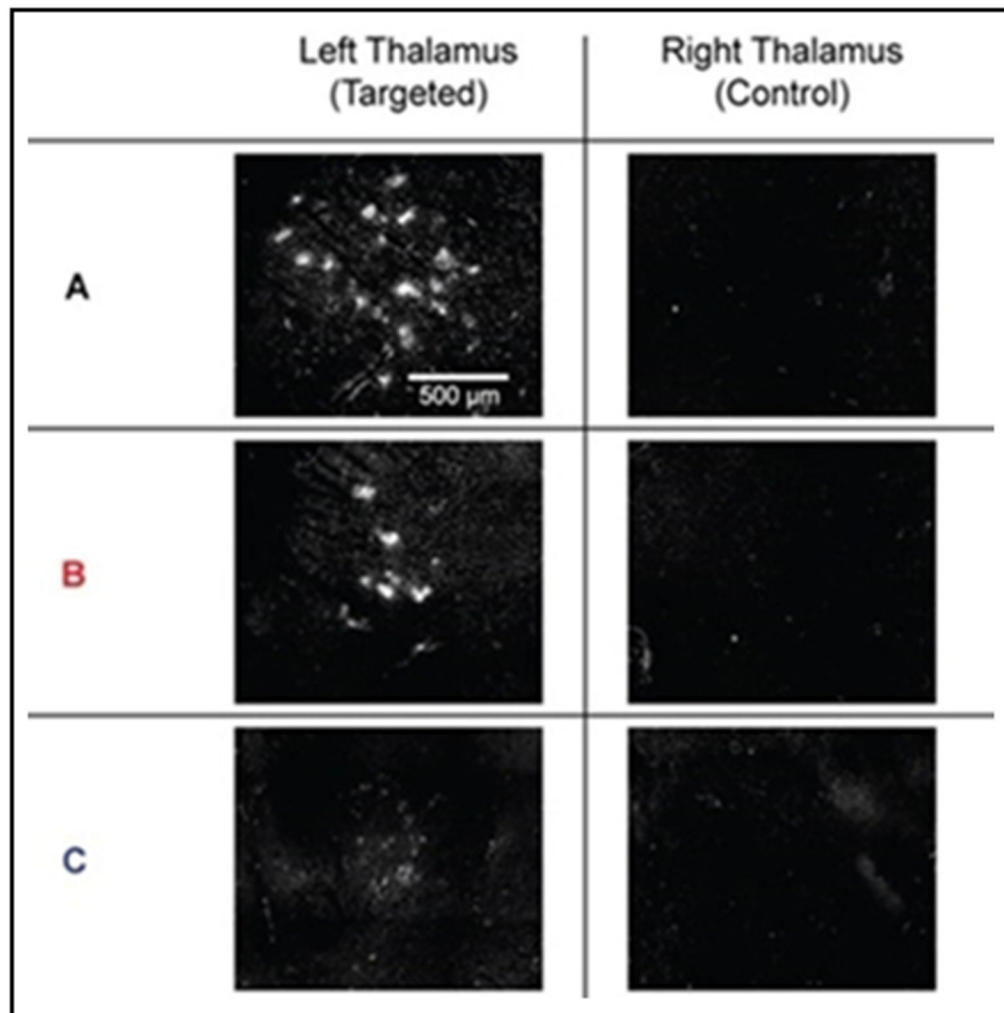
Fluorescence images from the delivery of Cy5-DNA-Au NPs across the BBB using focused ultrasound. There is a size-dependency associated with the delivery of Cy5-DNA-Au NPs across the BBB using focused ultrasound, with the smallest NPs tested in this study (A) delivered across the BBB six times more efficiently than the larger/largest NPs tested (B/C). A spot-like distribution of fluorescence was observed in the left thalamus, while no fluorescence signal is detected in the right thalamus. Reprinted with permission from John Wiley and Sons ⁶.
